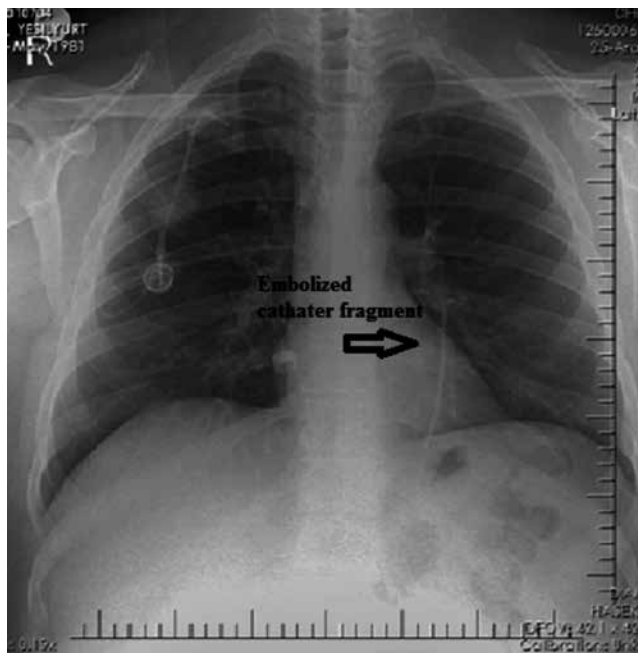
Chest radiograph of a 34 years old man shows cardiac migration of the fragment of a fractured portacath
